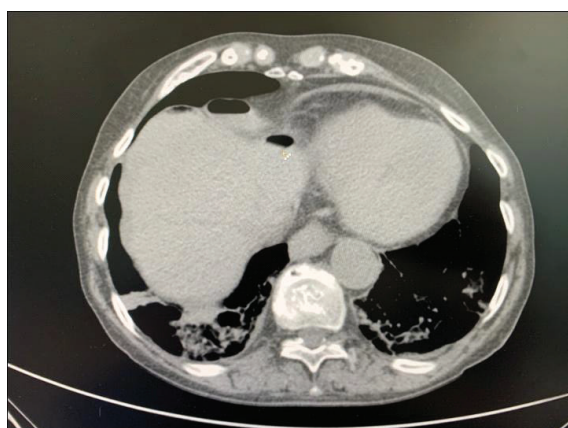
and 2b. Abdominal CT - subdiaphragmatically and down the anterior abdominal wall (with the patient lying on his back) free gas collections indicating perforation of the hollow organ
